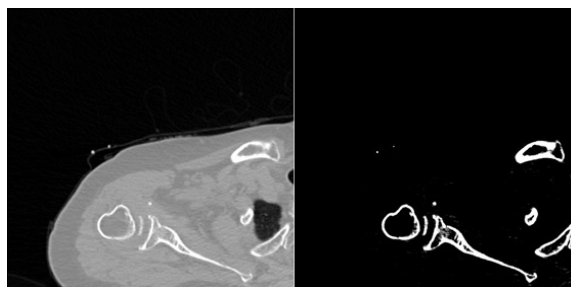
2D CT Scan image of shoulder (left), and contrast cut of same image to show only bones (right).
